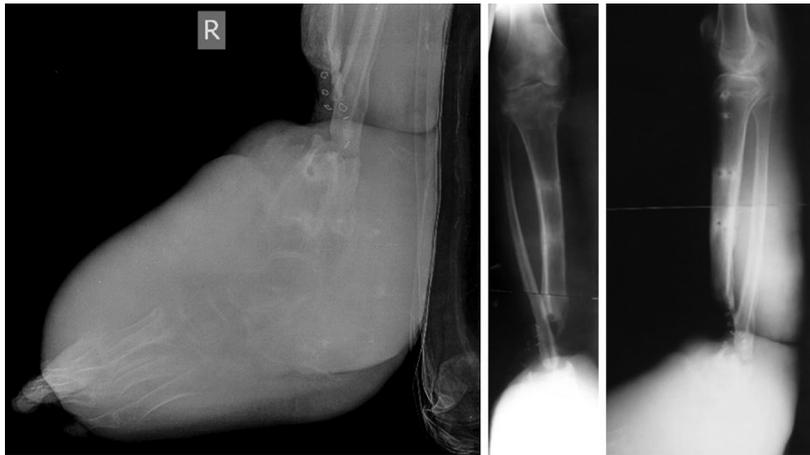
Radiographs of the right lower limb at admission. There is a post-traumatic defect-diastasis of the tibia and nonunion of the fibula on the background of marked osteoporosis
